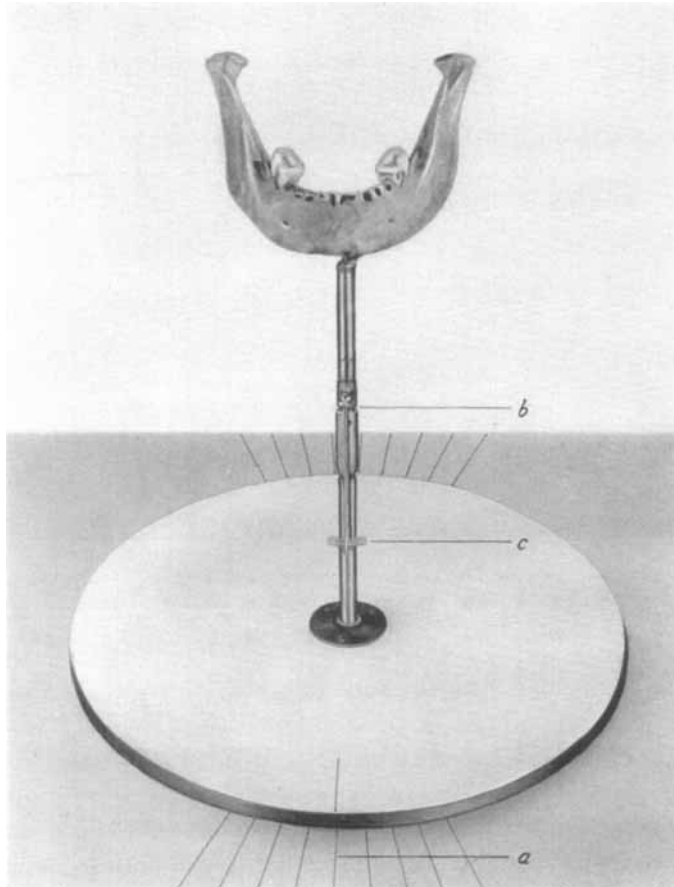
Apparatus for checking of tracings from roentgenograms. The degree of rotation around the vertical axle can be read from the scale (a) on the foot. Rotation around the sagittal axle (b) can be read from the frontal scale at (c).
